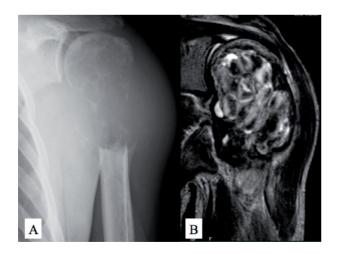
Patient 1. 1A: Radiographic image of the lesion of patient 1 at clinical presentation. 1B: T2-weighted MRI performed at the same time.
